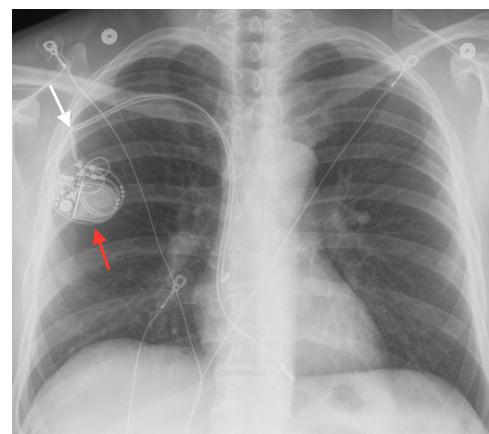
Chest radiograph - an example of a St. Jude transvenous dual chamber pacemaker (Assurity with magnetic resonance imaging compatible leads) with the generator in the right pectoral location (red arrow) and leads in the right atrium and right ventricle, as well as a potential site of lead damage (white arrow).
